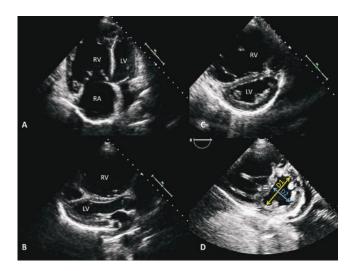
Two-dimensional echocardiography of RV and LV size and ventricular interdependence. A, Apical 4-chamber view showing an enlarged RV, where the RV is larger than the LV. B, Parasternal long-axis view with an enlarged RV and bowing of the septum into the LV chamber. C, Flattening of the ventricular septum, forming a D-shaped short-axis LV appearance. D, Representation of the end-diastolic eccentricity index, which is the ratio between the LV anteroposterior dimension (D1) and LV septolateral dimension (D2). LV: left ventricle; RA: right atrium; RV: right ventricle.
